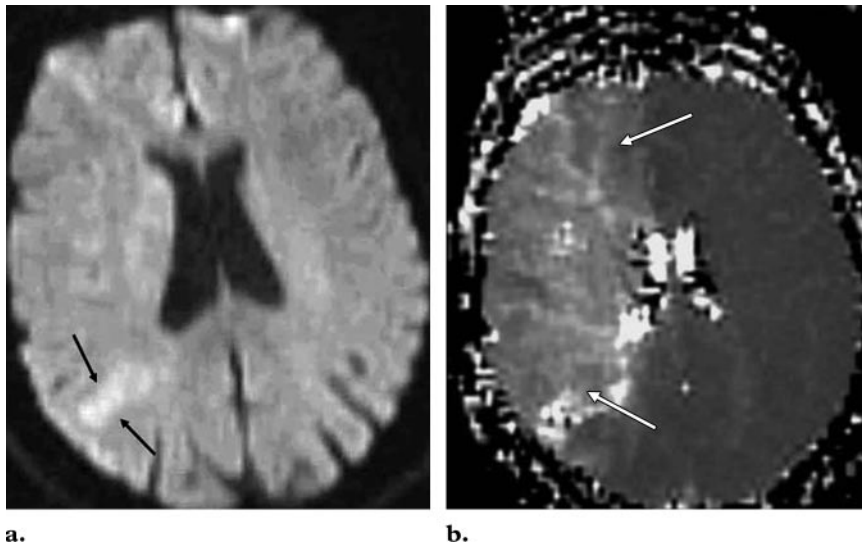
Acute stroke in a 67-year-old woman with acute left hemiplegia 2 hours after carotid endarterectomy. (a) Diffusion-weighted MR image ($b = 1000 \text{ sec/mm}^2$) shows an area of mildly increased signal intensity in the right parietal lobe (arrows). The ADC values in this region were decreased. (b) Perfusion-weighted MR image shows a larger area with increased time to peak enhancement (arrows) in the right cerebral hemisphere. The mismatch between the perfusion and diffusion images is indicative of a large penumbra.
